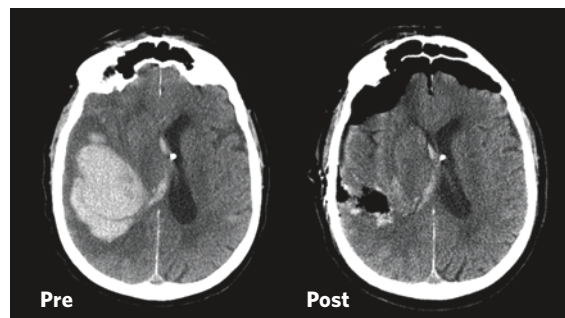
Non-contrast CT pre/post surgery showing a 95% hematoma removal with resolution of mass effect and midline shift.
